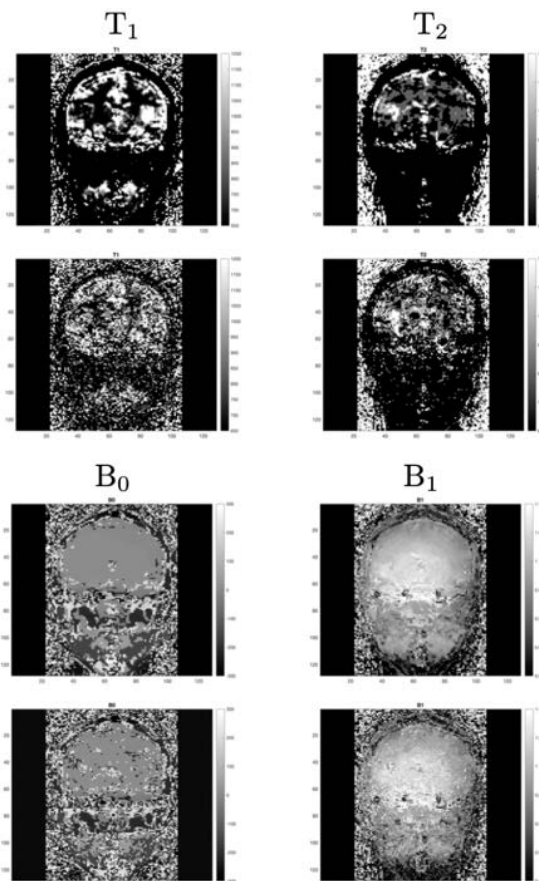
Proof of concept reconstruction of different MRI parameters (Relaxation times T_1, T_2 , magnetic field homogeneity B_0 , and radiofrequency transmit field B_1) using brute-force (top rows) and SB-LSH (Picture: M. Hürbin).
